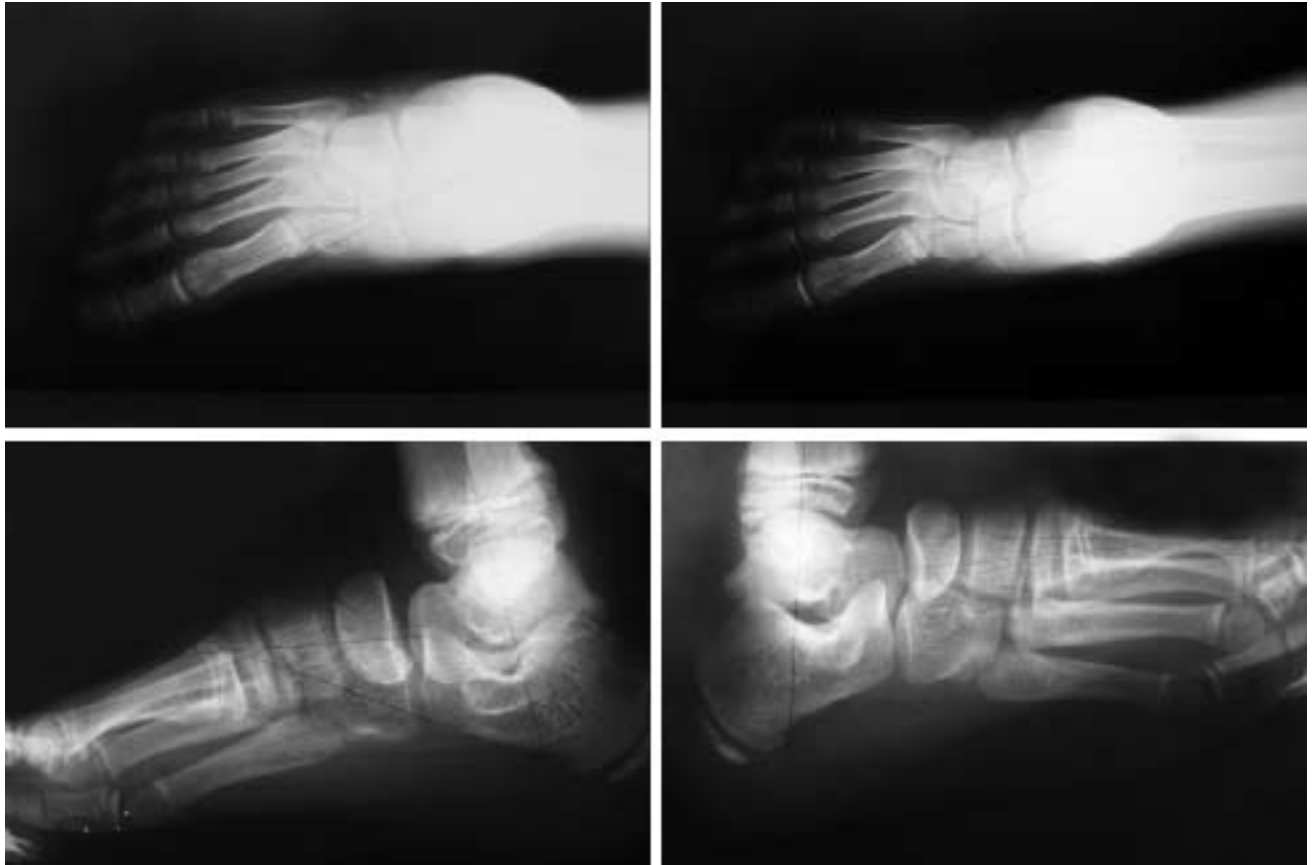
Radiographs of a patient taken 9 years after the bilateral complete subtalar release.
